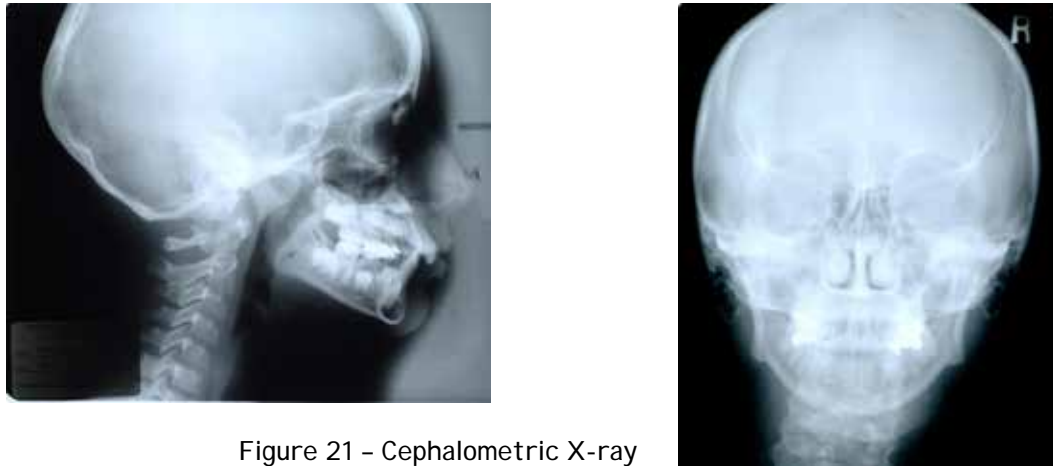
Cephalometric X-ray
